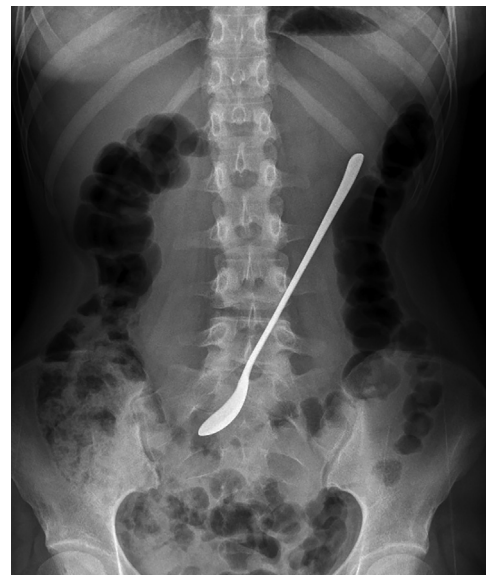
Abdominal roentgenogram revealed a long radiopaque object in the stomach.
